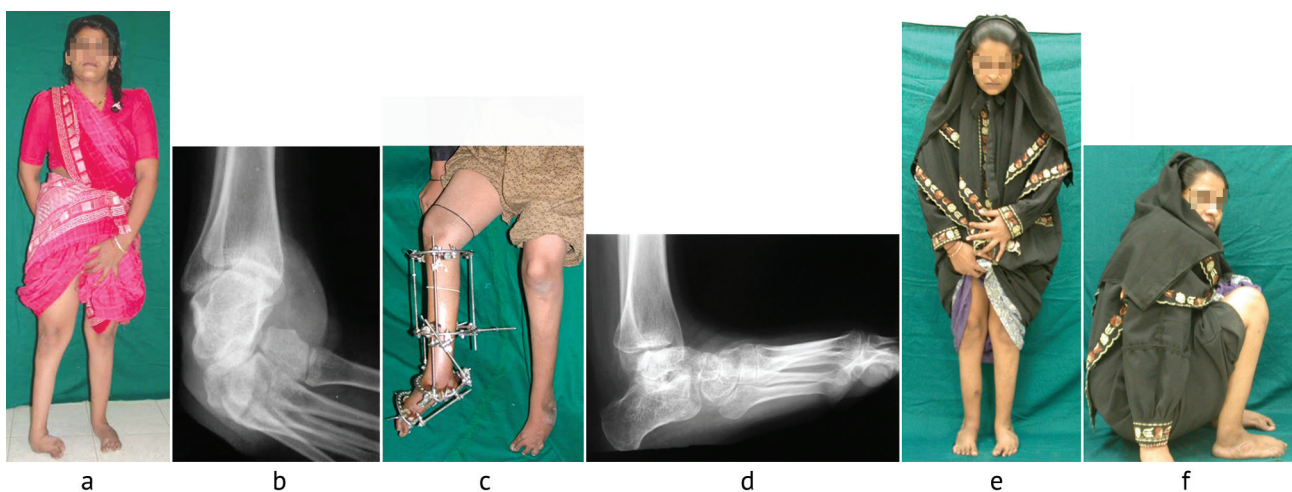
(a, b) 33-year old mother of three with neglected clubfoot with severe deformity. Talar dome is not flattened and hence she is amenable to soft tissue distraction; (c) Ilizarov fixator applied with two rings in the tibia. Due to a large foot size, a half-ring is used to fix the talar wire, which is then connected to the lower tibial ring. Forefoot and hind foot rings are now connected in third stage to correct equinus (first stage is correction into supination, second stage is correction of forefoot abduction; both these stages requiring separate montages of the Ilizarov fixator). Notice: the hindfoot motors angled posteriorly to correct equinus deformity; (d) X-ray shows full correction of deformity with a congruent ankle joint; (e, f) good clinical correction with ability to squat denoting restored dorsiflexion
